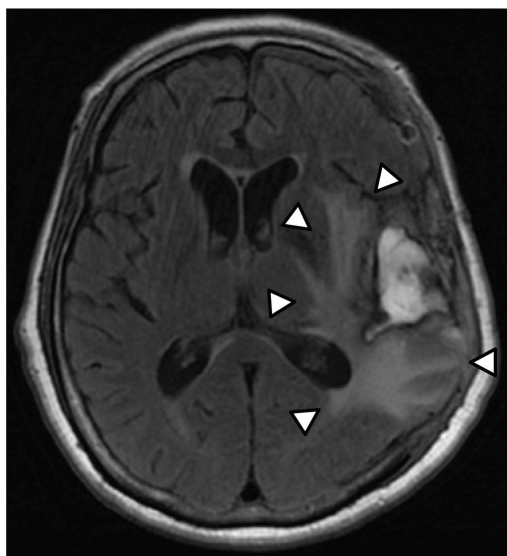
Head magnetic resonance imaging (MRI) on day 25. Brain edema is shown as a high signal intensity (arrowheads) on fluid-attenuated inversion recovery (FLAIR) imaging.
